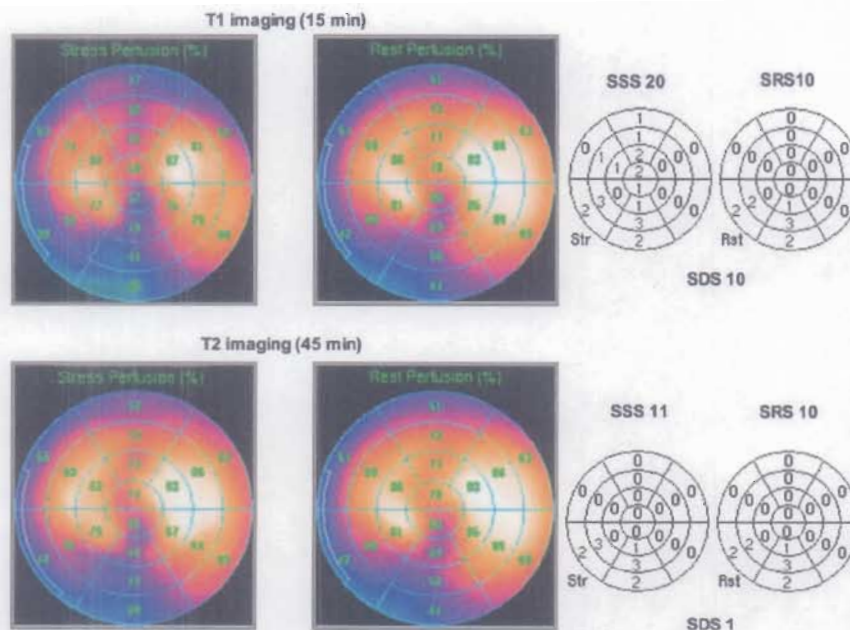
Perfusion bull's eyes (left) and relative quantitative perfusion SPECT scores (right) in patient with previous myocardial infarction and double-vessel disease. (Top) Early imaging identified fixed perfusion defect of inferior wall and reversible defect of anterior and antero-septal walls, resulting in SDS of 10. (Bottom) Standard delayed imaging failed to identify reversible defect in territory of left anterior descending coronary artery, resulting in SDS of 1. Therefore, 2 different clinical messages were obtained from same patient: previous inferior myocardial infarction plus anterior myocardial ischemia using early imaging and previous inferior infarction without ischemia using standard delayed scans.
